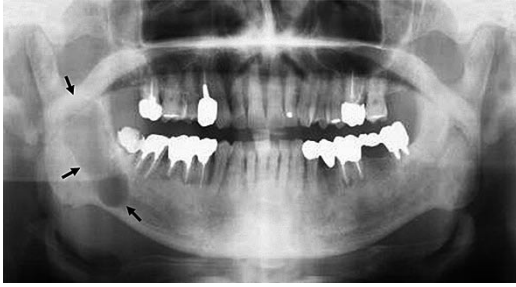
Panoramic radiography showing a large, unilocular, radiolucent lesion with distinct borders involving the right mandible, extending from the second molar to the upper portion of the ramus (arrows).
